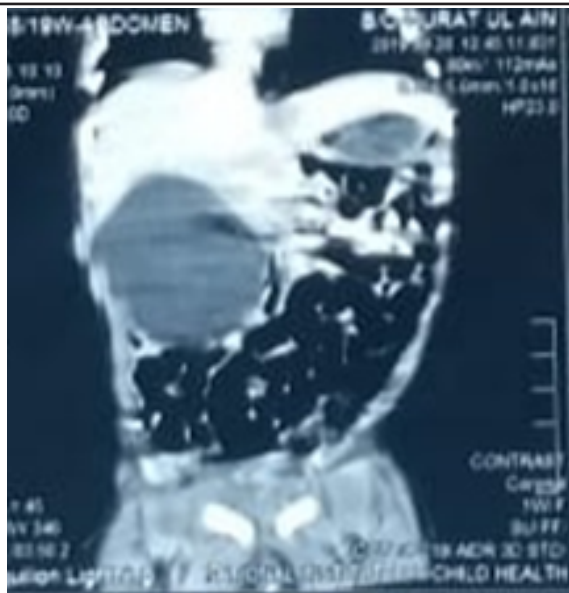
I a) Swelling in umbilical region with impression of omphalocele minor. b) CT scan showing large homogenous cyst in right upper abdomen.
